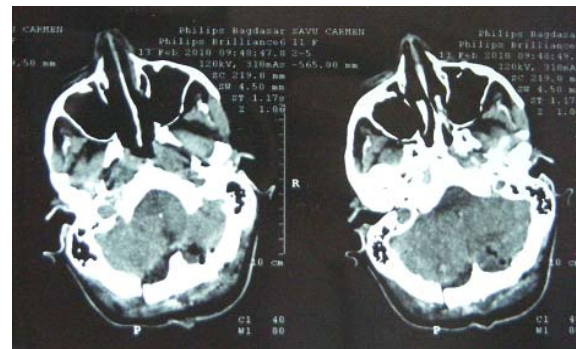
Postoperative enhanced CT-scan (second day after the intervention)
